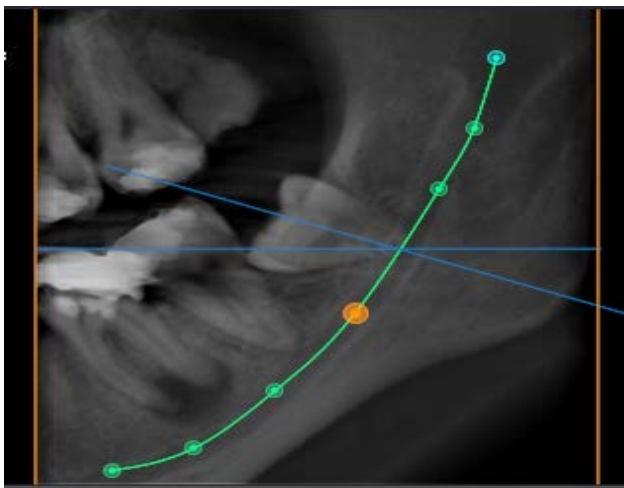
The axial cross-section analysis of the Cone Beam Computed Tomography (CBCT) image shows preserved diameter of the mandibular canal (class 2, subtype 2b).
